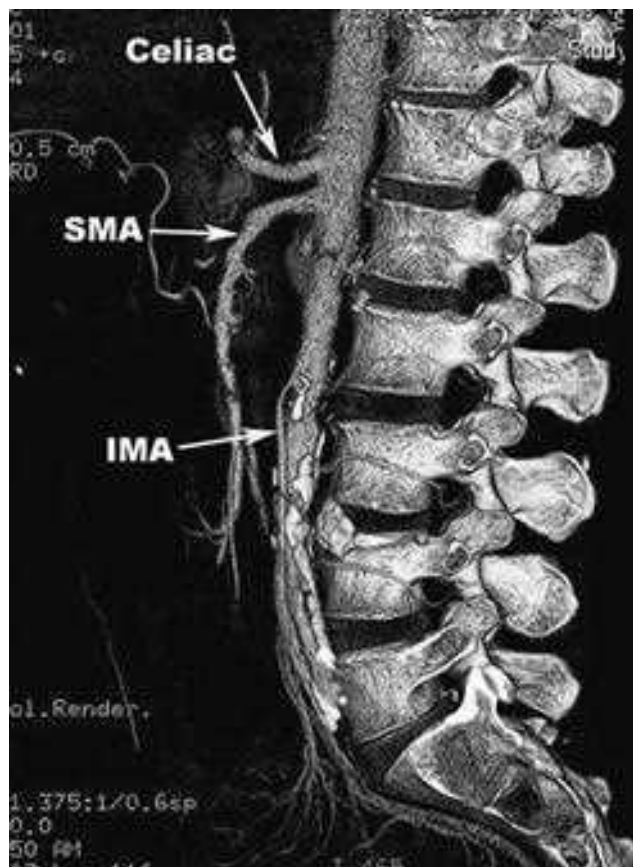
Computed tomography angiogram of the abdomen with three-dimensional reconstruction provides a clear view of the celiac artery, superior mesenteric artery (SMA), and inferior mesenteric artery (IMA).
